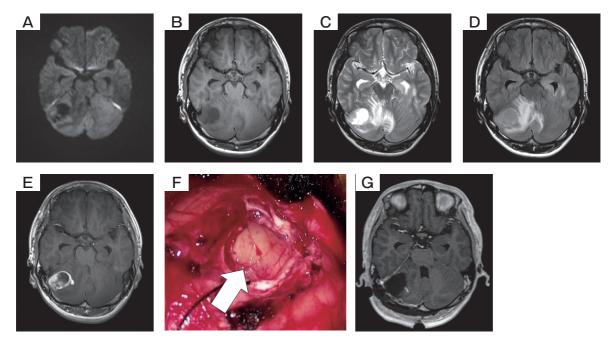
Pre and postoperative MRI during the patient's first surgery. Head MRI before the initial surgery revealed a ring-like enhanced lesion in the right cerebellum (A, diffusion-weighted image; B, T1-weighted image; C, T2-weighted image; D, fluid-attenuated inversion recovery image; E, contrast-enhanced T1-weighted image). The fluid-attenuated inversion recovery image showed peritumoral edema (D). Intraoperative findings showed a brownish, soft, and internally hemorrhagic tumor. The border with the normal parenchyma was not discernible. An arrow indicates the tumor tissue lying underneath the normal cerebellar cortex (F). Postoperative MRI shows gross total resection of the contrast-enhanced lesion (G). MRI, magnetic resonance imaging.
